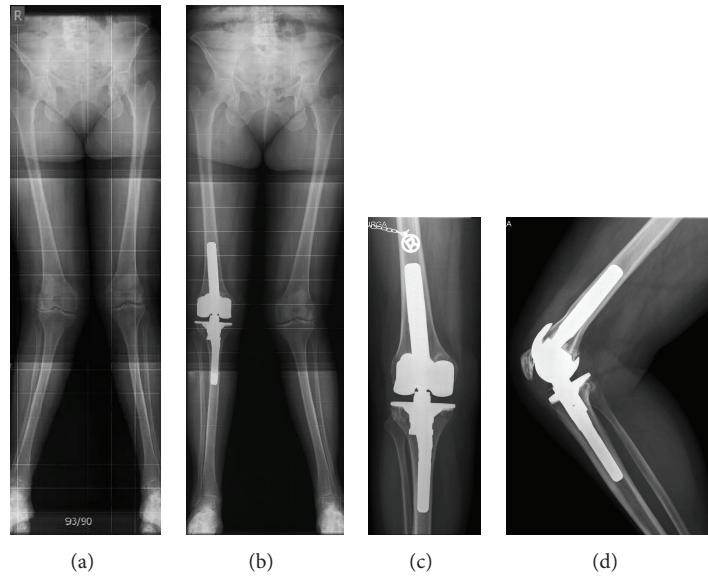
(a) Preoperative long standing X-ray of 73-year-old female with 22° valgus deformity. (b) Postoperative longstanding X-ray. (c) Detail X-ray—ap view. (d) Detail X-ray—lateral view.
